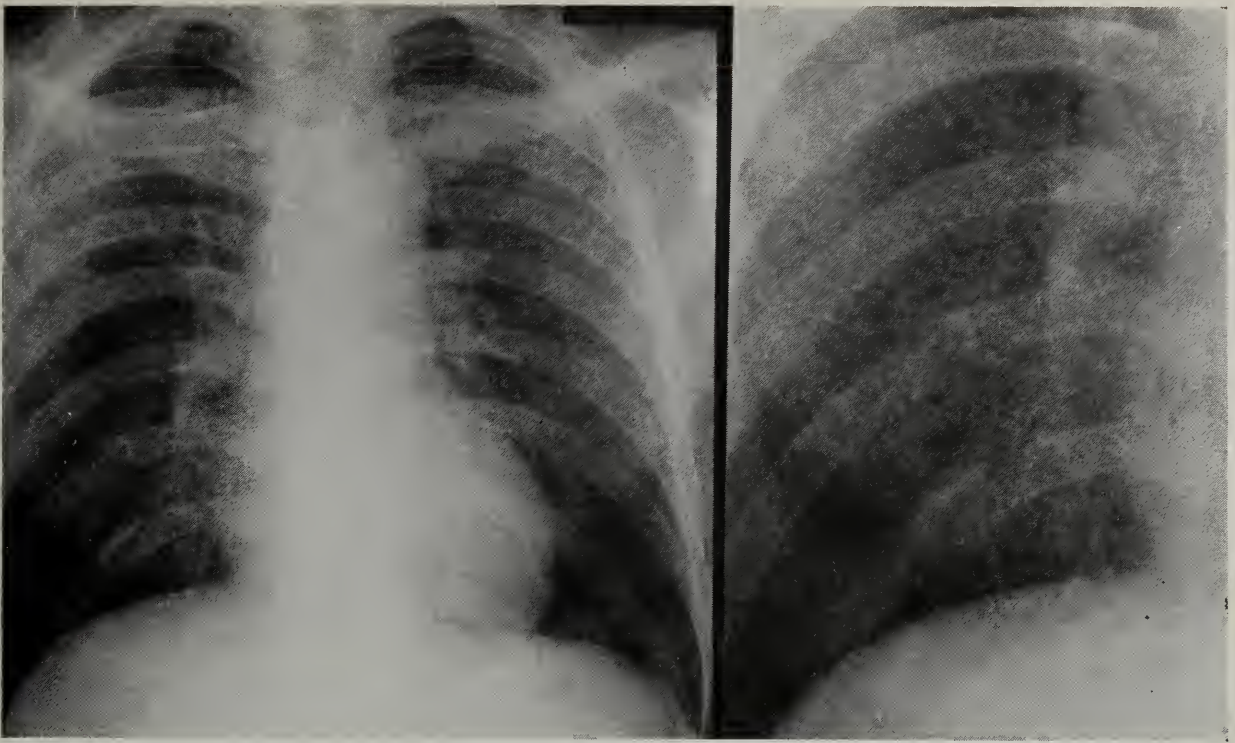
(same case as Figure 5).—Readmitted 28 December 1964, with fever, night sweats, 40 pound weight loss and right hip pain. X-ray film of chest showed a diffuse miliary pattern involving both lung fields. A magnified detailed view of the right lower lung is included. The coccidioidin skin test was now negative at 1:100 and 1:10 dilutions, indicating anergy. The complement fixation was 1:256 initially, and rose to 1:1024 in two months. Amphotericin B was begun on 5 January 1965. Culture of aspirate from right hip produced *C. immitis*. Follow-up chest films showed gradual resolution and almost two years later was essentially normal. Complement fixation 1:256 at two years.
